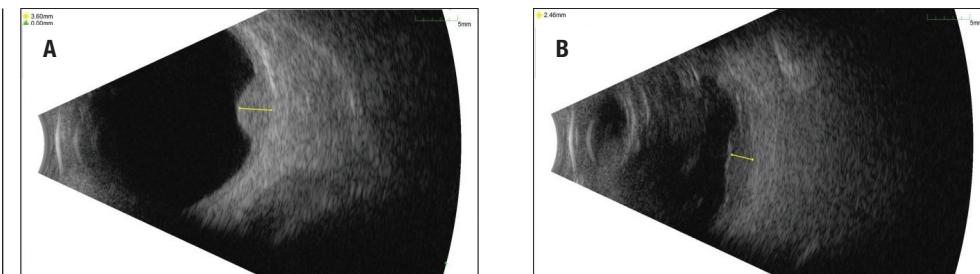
B-scan ultrasound at two months postoperatively reveals a (A) dome-shaped choroidal mass superonasally at 10 o'clock with maximal height 3.60 mm, and (B) a diffusely corrugated choroidal mass inferiorly at 6 o'clock with maximal height of 2.46 mm.
